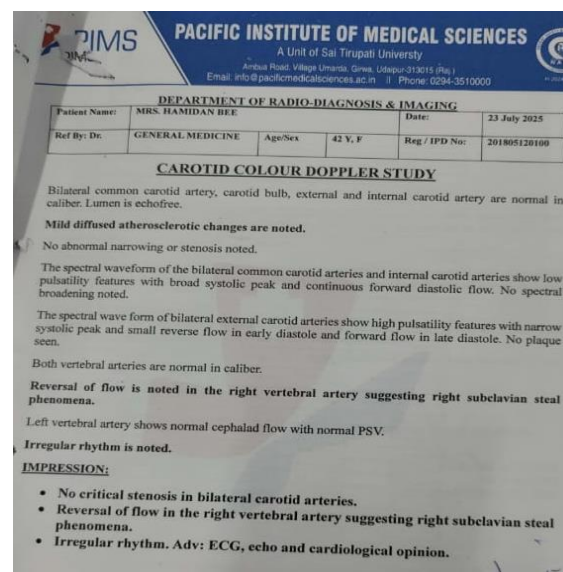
Carotid colour Doppler study.
